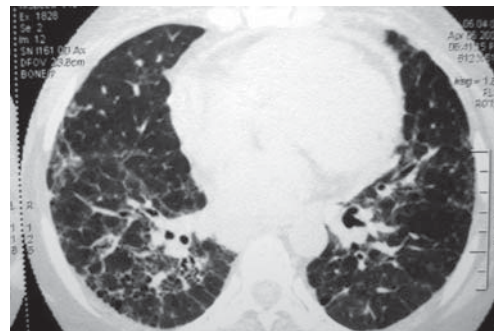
HRCT thorax revealed reticulonodular shadows, ground glass opacity, honey combing, interstitial thickening, affecting predominantly basal parts in both lungs, suggestive of idiopathic pulmonary fibrosis
